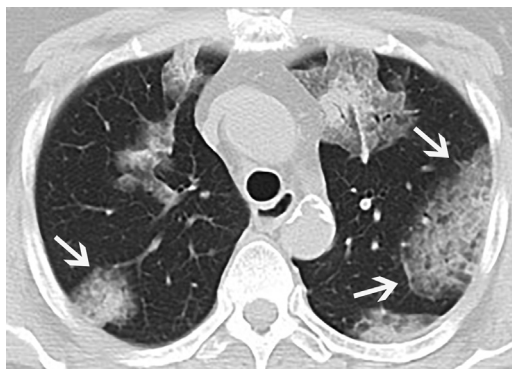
Rhodococcus equi* pneumonia. Axial CT shows large, rounded, ground-glass opacities in the periphery of both lungs (arrows). A geographic ground-glass pattern is observed in the anterior upper lobes. Patient presented with advanced AIDS and a CD4 cell count less than 100 cells/ μ L.
